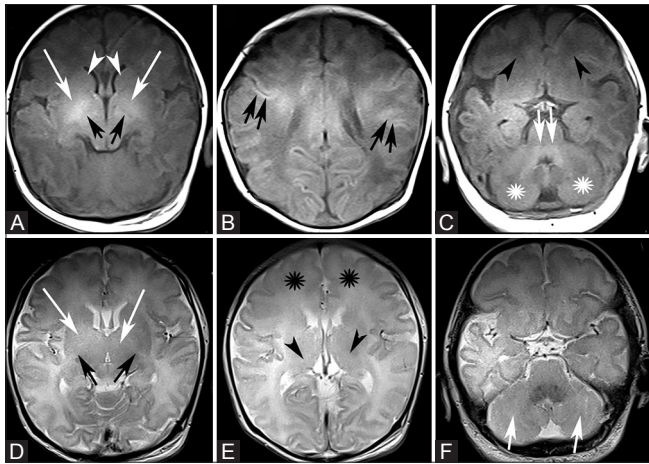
(A-F): This is an MRI brain of a term neonate who had been classified as moderate Samat clinically. T1W (A-C), T2W (D-F). (A-C) Absent myelination [black arrows] of PLIC, on T1WI (3 + 3). Normal caudate nucleus (0 + 0) [white arrowheads]. Abnormal signal in globus pallidus/putamen (3 + 3) [white arrows], thalamus (1 + 1) (not shown) and cortex (1 + 1) [double black arrows] on T1WI. Abnormal signal in brainstem (1 + 1) [double white arrow], cerebellum (1 + 1) [white stars] and white matter (1 + 1) [black arrowheads] on T1WI. (D-F) On T2WI there is also absence of PLIC myelination (3 + 3) [black arrows]. Normal signal of caudate nucleus (0 + 0). However abnormal signal of globus pallidus/putamen (3 + 3) [white arrows] and thalamus (2 + 2) [black arrowheads] on T2WI. Abnormal signal in cerebellum (1 + 1) [black arrows] and white matter (2 + 2) [black stars] on T2WI. No areas of restricted diffusion on DWI and ADC images (not shown). Therefore, the total score is 44 which is classified as severe HIE. The child, however, had normal developmental outcome at 2 years of age
